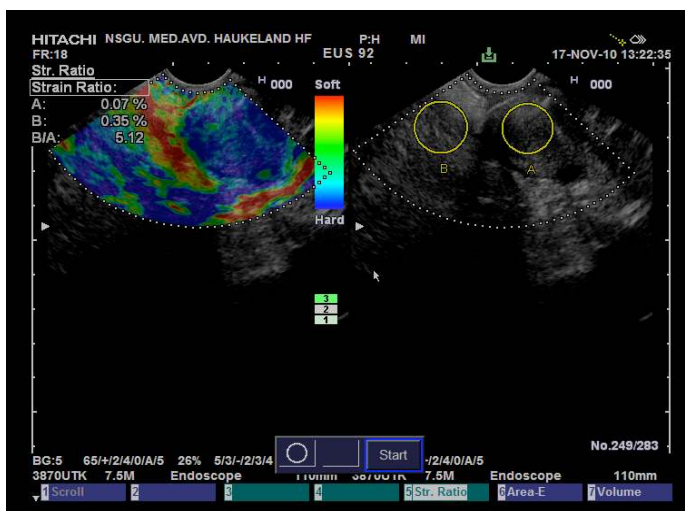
Endoscopic ultrasonography with RTE shows an adenocarcinoma in the pancreas. Elastogram (left) shows blue colour indicating low strain corresponding to hypoechoic tumour tissue in B-mode (right). A strain ratio between reference (circle B) and tumour tissue (circle A) yields a SR of 5.12.
